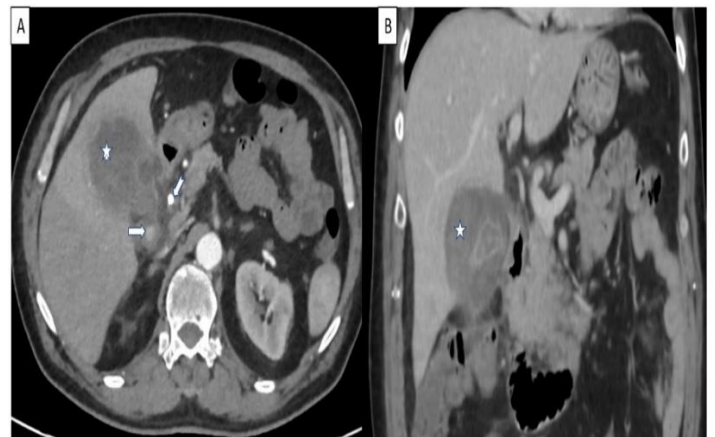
Upper abdomen CT showed a nodular lesion in the portal venous phase. The lesion was thought to be a gallbladder stone. The following imaging modalities revealed that was a pseudoaneurysm (arrow)
